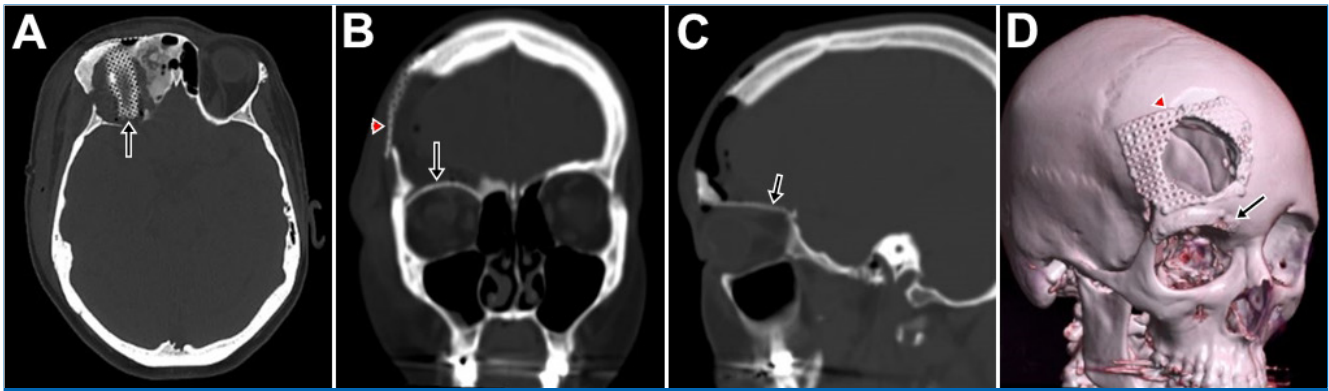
Immediate and postoperative CT scan images with no contrast medium injection. (A) Axial cut showing the titanium plate well-adapted in the right orbital roof and right frontal bone area; (B) Coronal cut showing the titanium plate well-adapted in the right orbital roof and right frontal bone area; (C) Sagittal cut showing the adaptation of the titanium plate in the right orbital roof with discrete zones of subcutaneous emphysema surrounding it; (D) 3D reconstruction of both well-adapted titanium plates.
